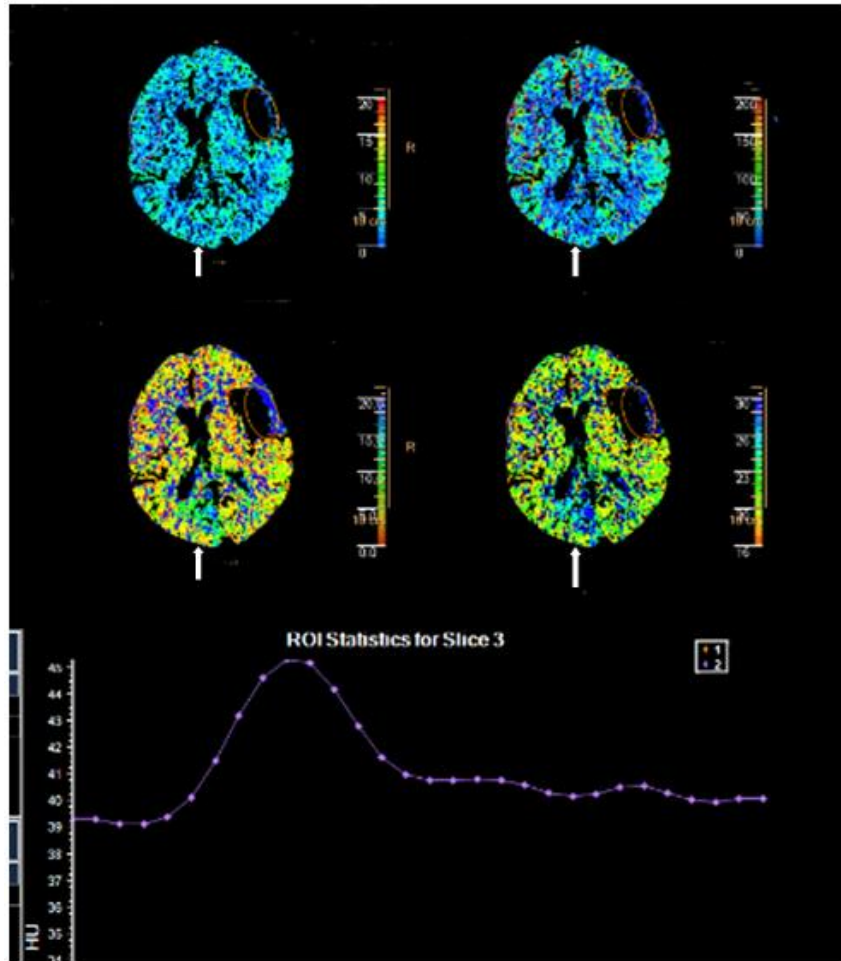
Hypoperfusion in the PCA irrigation area of the right occipital lobe that was not visualized in the normal CT was remarkably encountered in the baseline perfusion CT (arrows)
